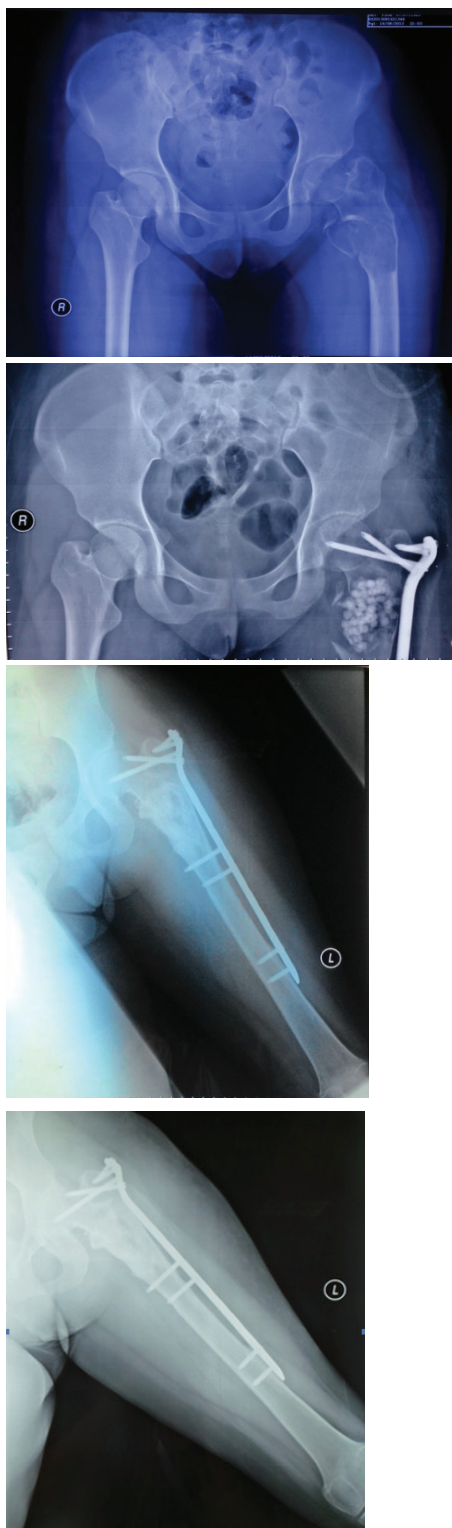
Hip and Femur X-Ray of Curettage therapy in SBC patient: A. Before surgery; B. Month 1 after surgery; C. Month 6 after surgery; D. Months 12 after surgery.
